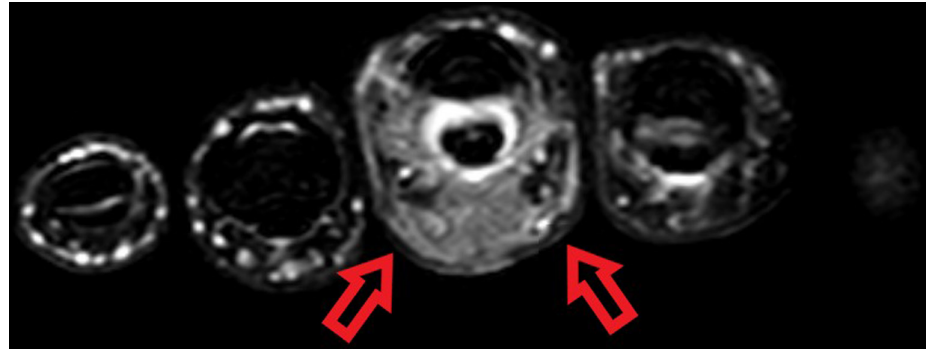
Left middle finger showing marked tendon sheath thickening (axial fat-saturated T2-weighted MRI).
